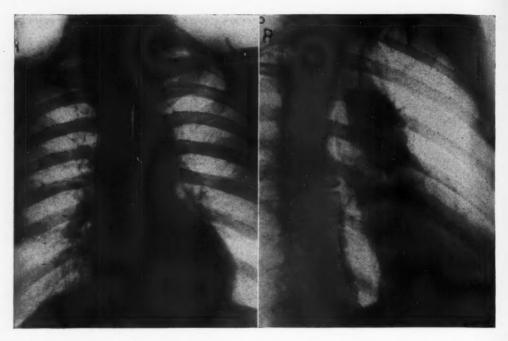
and 4b (169871). Roentgenograms of aorta in third position: (a) anterior-posterior view; (b) oblique view.
